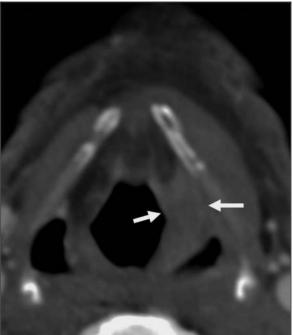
Laryngoscopy and multi-row CT of the larynx. At laryngoscopy a thickening of the left arithenoid and the corresponding glosso-epiglottic fold is demonstrated (a, arrows). Axial multi-row CT image (b) and 3D endoluminal view (c) confirm the presence of a larynx cancer (arrows)
